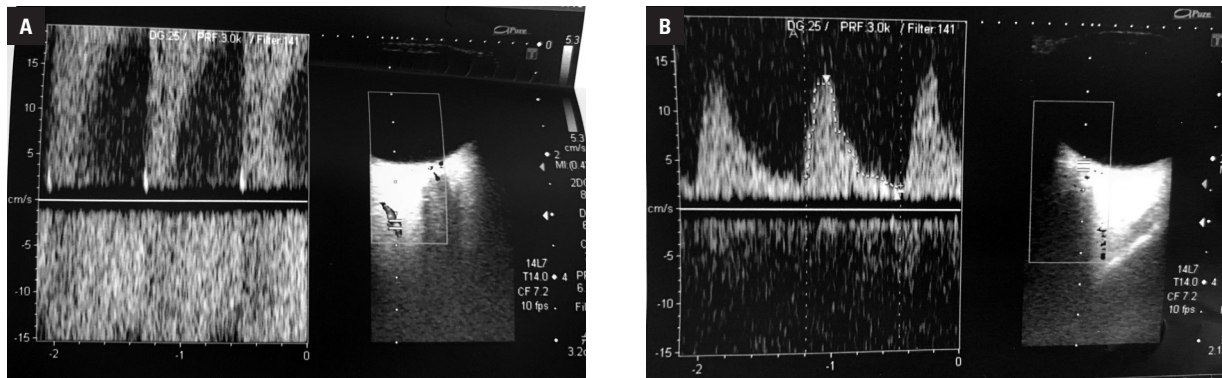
Color-coded duplex ultrasonography (Toshiba Xario, Model SSA-660A, Tokyo, Japan): A. Doppler signal of an inverted right ophthalmic artery flow due to right ICA stenosis (over 90%) showing negative velocities; B. Doppler ultrasound (DUS) of right central retinal artery
